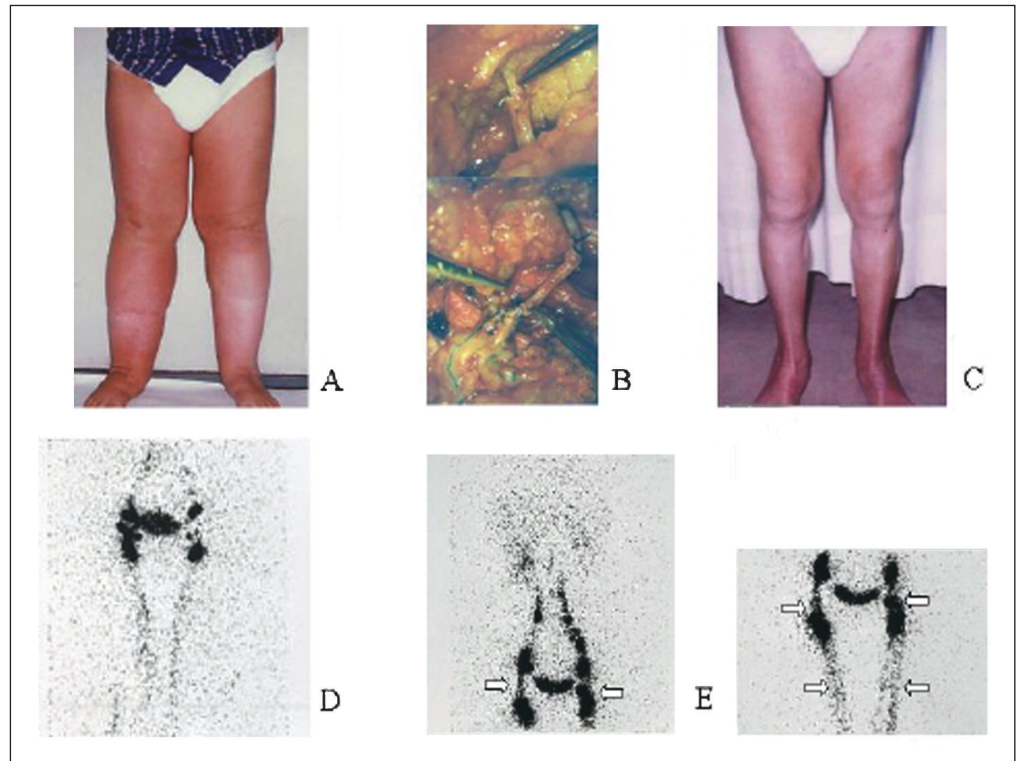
Primary lower-limb lymphedema (A), treated by LVLA (B), with 10-year follow-up after microsurgery (C). Lymphoscintigraphy - pre-op (D) and post-op (E) - shows preferential lymphatic pathways and interposed vein grafts (arrows).
